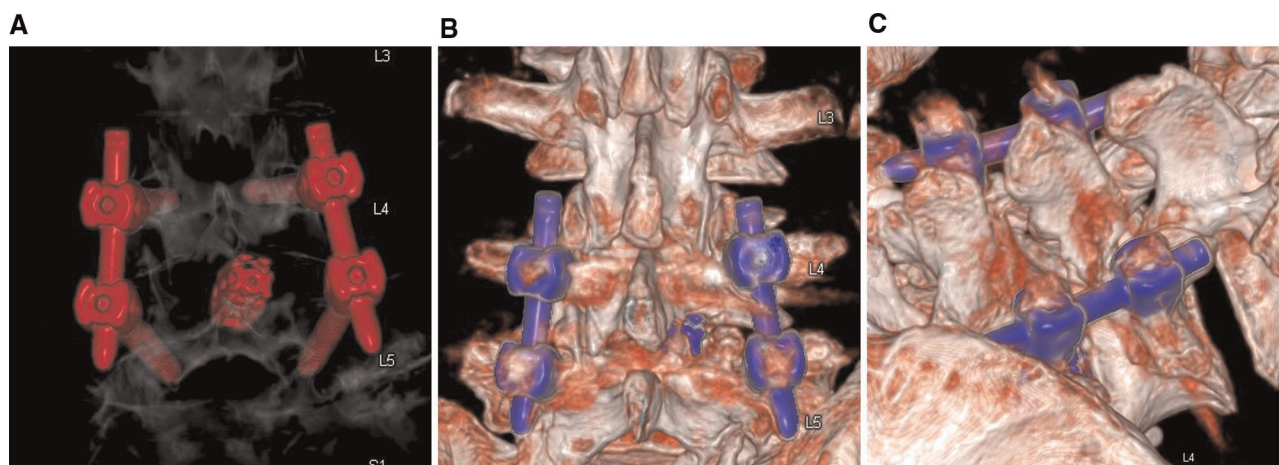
CT reconstructed images. (A,B) The extent of intraoperative laminectomy and facetectomy. (C) The base of the spinous process is excised.
